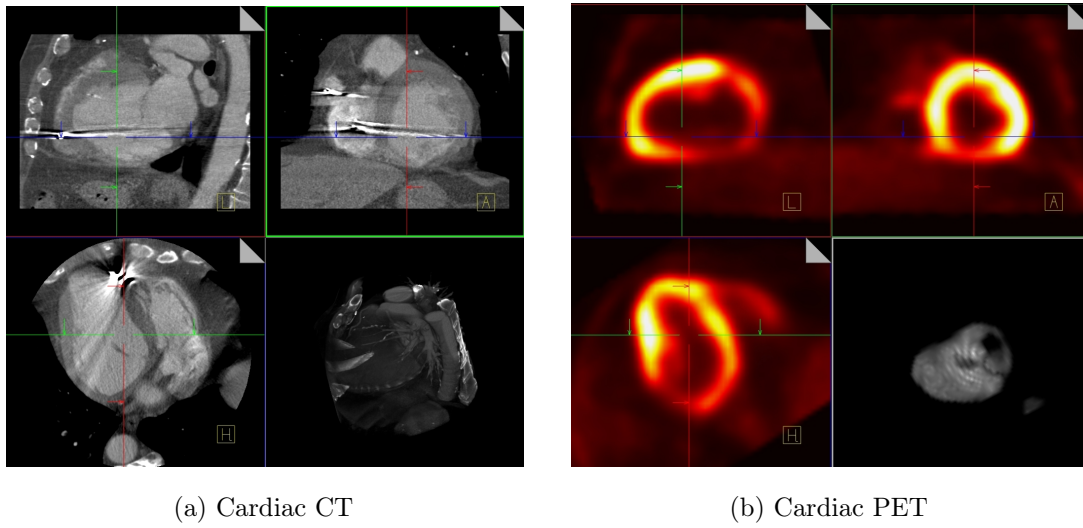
Three orthogonal views plus a 3-d volume rendering of a patient cardiac scan in two modalities: (a) CT, and (b) PET.
